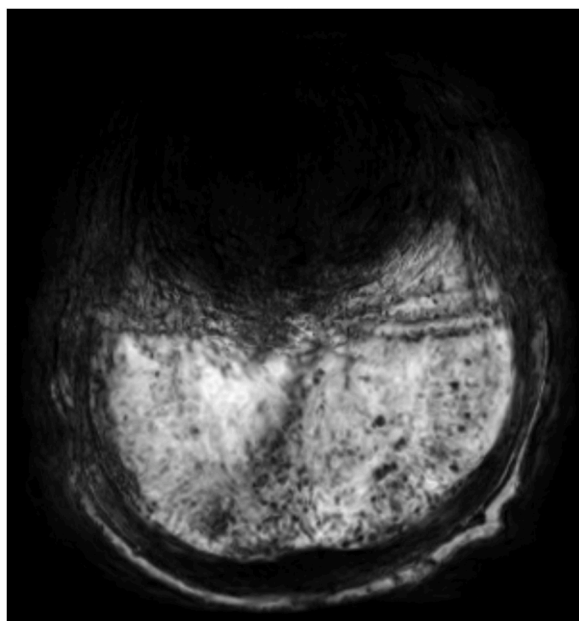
Magnetic resonance imaging study (MRI) of brain showing multiple microhemorrhages.
